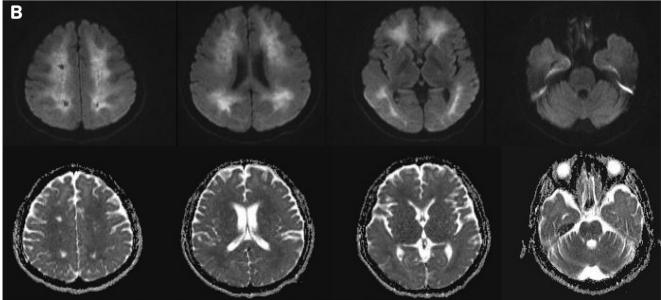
(A) Brain MRI 47 days after the onset of the insult showed diffusely increased signal intensity in the periventricular white matter on FLAIR sequence. Several small vacuolar lesions in bilateral corona radiata were also found (arrow). (B) High signal changes on DWI (upper column) and minimal low signal changes on ADC mapping (lower column) were noted.
